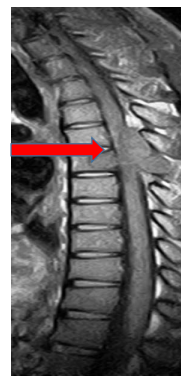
Spinal MRI showing a vertebral body in low signal intensity on T1 at the level of T2 thoracic vertebra.
